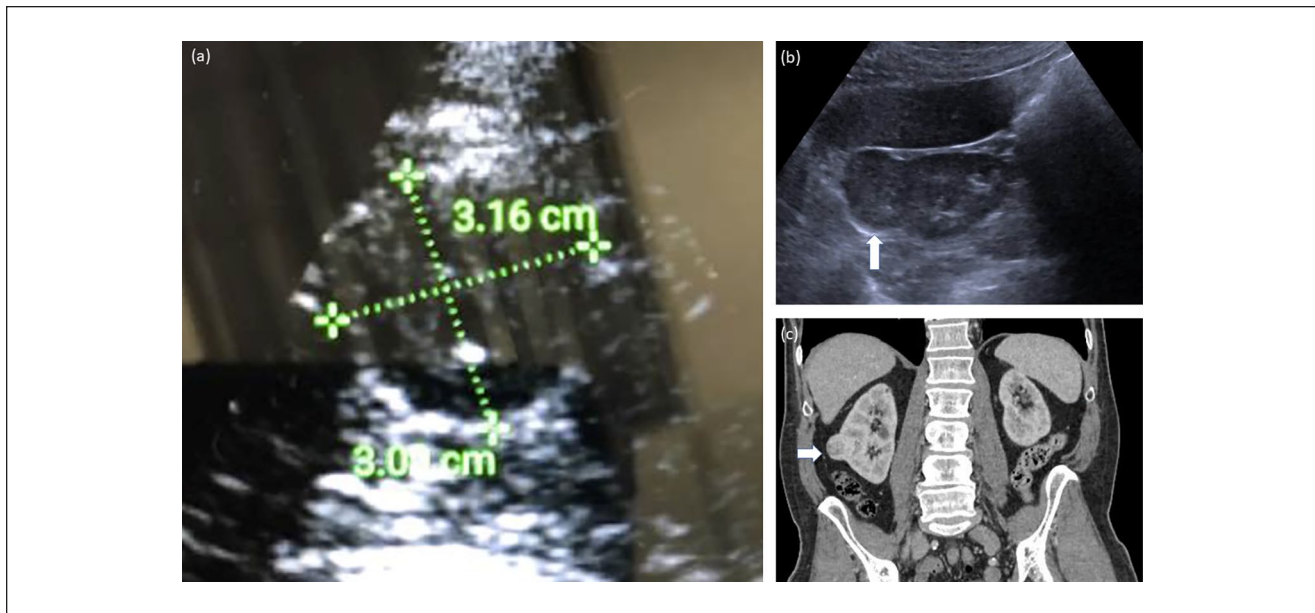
(a) Point-of-care ultrasound image of right kidney in an asymptomatic 69-year-old man with a history of tobacco use shows a heterogeneous solid mass measuring approximately 3 cm in its largest dimension. (b) Formal renal ultrasonography image of a peripherally located solid mass (arrow) found in the right kidney, measuring 3 cm in its largest dimension. This mass demonstrated increased blood flow (not pictured) consistent with renal cell carcinoma. (c) Contrast-enhanced computed tomography imaging of the abdomen and pelvis, coronal view shows a peripheral mass (arrow) on the right kidney with no evidence of renal vein involvement or metastatic disease in the rest of the abdomen.
